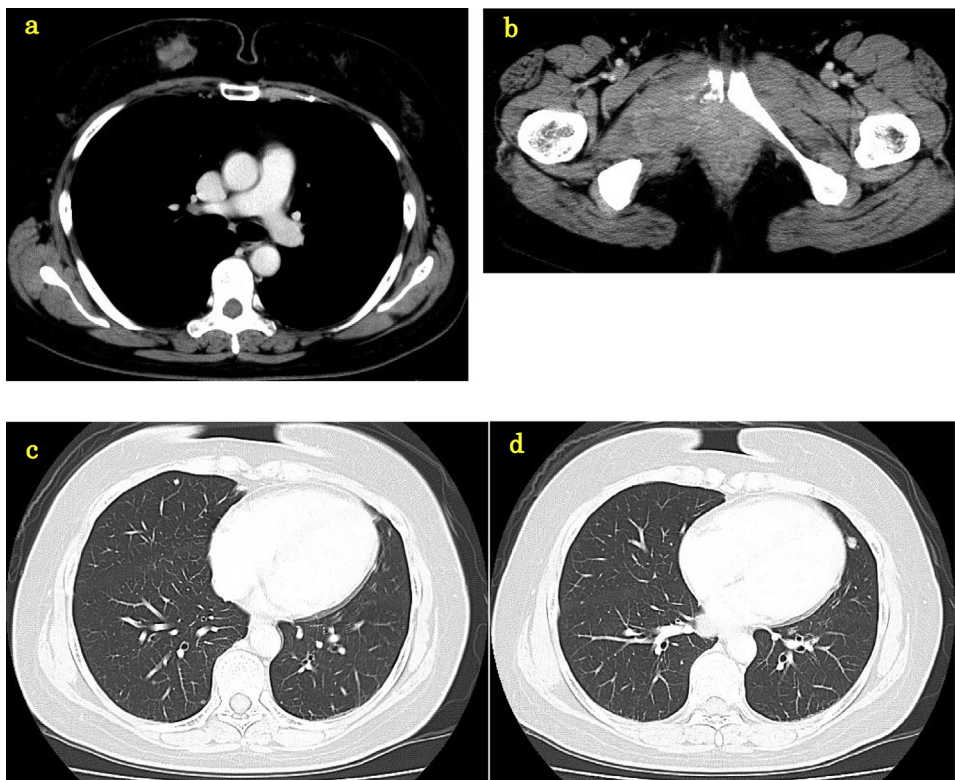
Computed tomography. a. Computed tomography image showed right breast tumor. b. Computed tomography image showing right pubic tumor with osteolysis. c, d. Note the multiple lung metastases.
